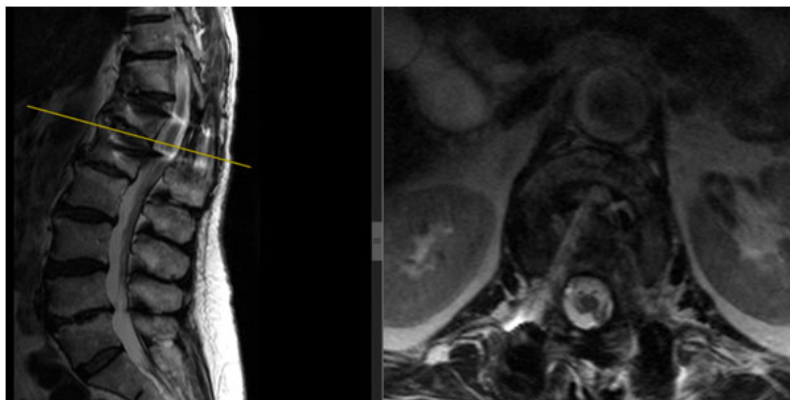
One-year postoperative MRI showing no compression, no residual disc fragments
